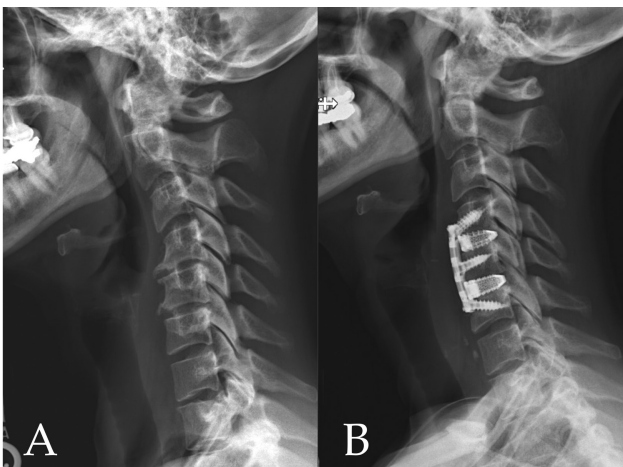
(A) Preoperative and (B) postoperative X-rays of patient 2 showing the C4-6 anterior cervical discectomy and fusion.
